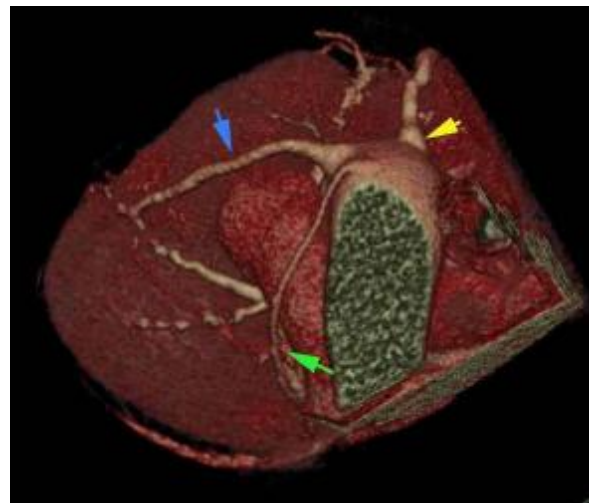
This patient was to undergo hip surgery and had a history of a CABG 12 years ago, with no operative notes. He had mild chest pain and a catheter angiogram showed a normal SVG-RCA and SVG-OM, but no other graft could be found / engaged. The LIMA was not grafted to any artery and was normal. The LAD was occluded proximally. To confirm a grafted LAD, a cardiac CT was performed. It showed an SVG-LAD graft (blue arrow), which was normal and patent, along with the SVG-RCA (yellow arrow) and SVG-OM (green arrow) grafts.
